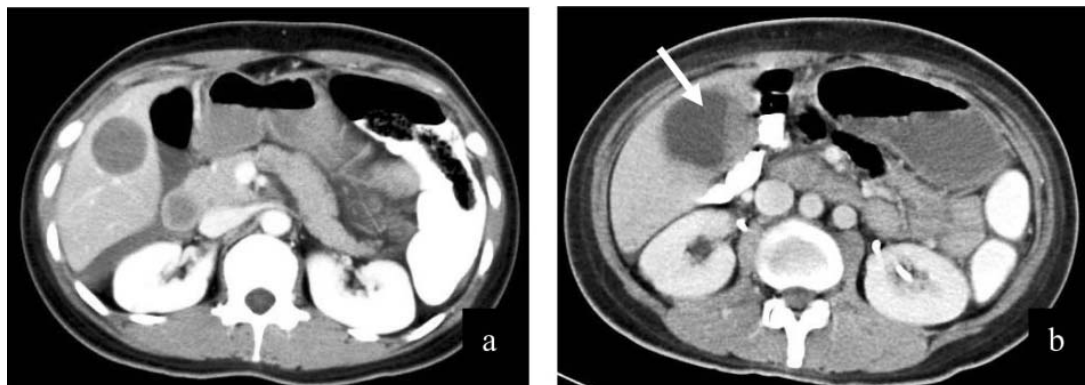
Contrast-enhanced CT scan of abdomen in a 30-year-old woman with metastatic GIST at liver and received imatinib for 1.5 months. Pretreatment image: (a) showed homogeneous low density mass in the liver. There was increase in size of the lesion with a newly developed intralesional solid nodule (arrow) (b).
